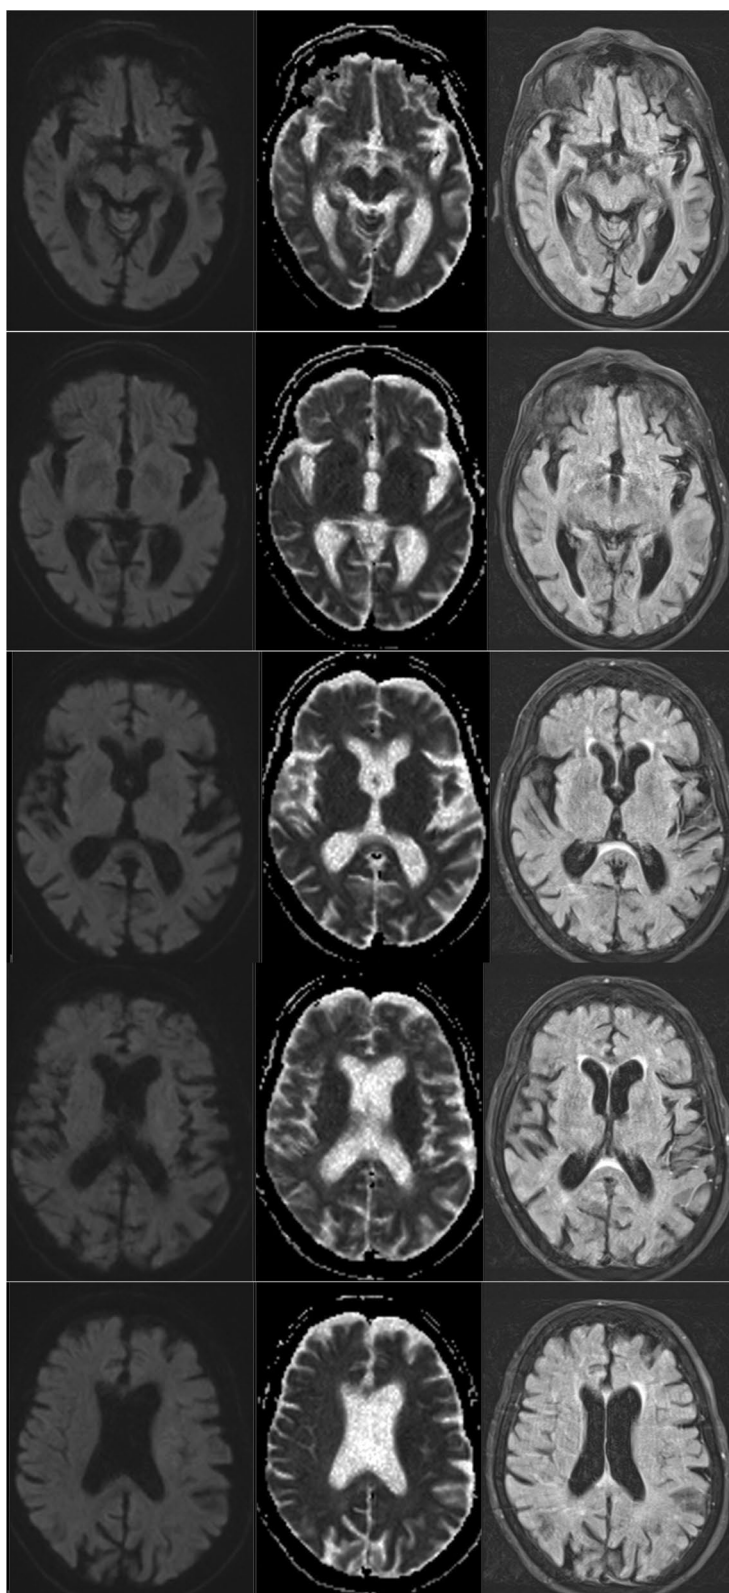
MRI Findings (done within 4 h from complaint starting); showing No areas of restricted signal could be noted at the DWI or ADC map. Prominent high SI vessels at the left temporal region and Sylvian fissure on FLAIR images may suggest early sign of ischemic vascular insult
